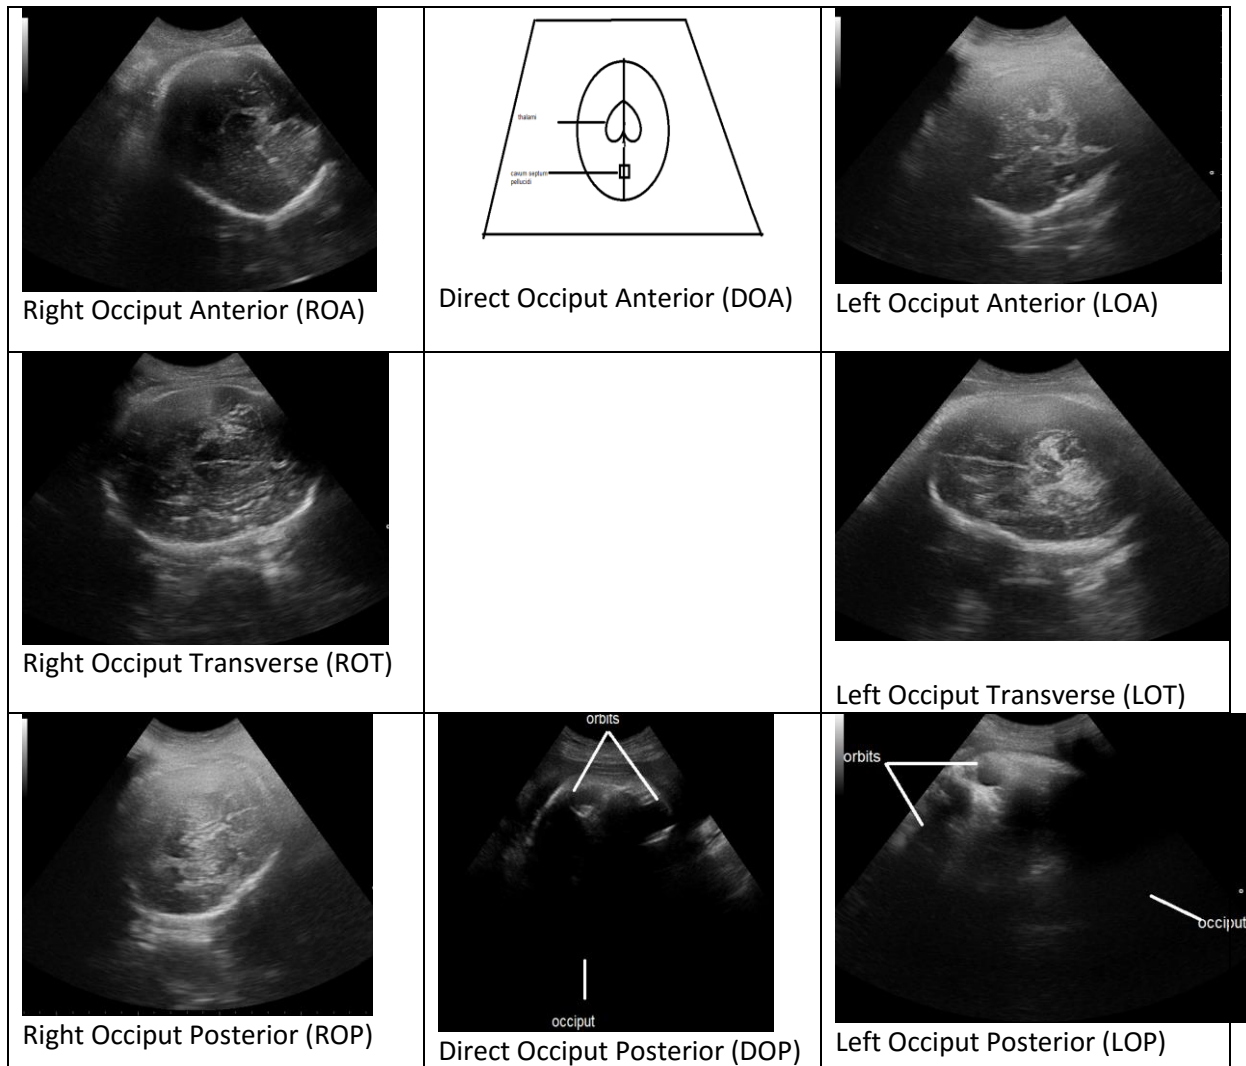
Sonograms of the various fetal head positions of some cases
